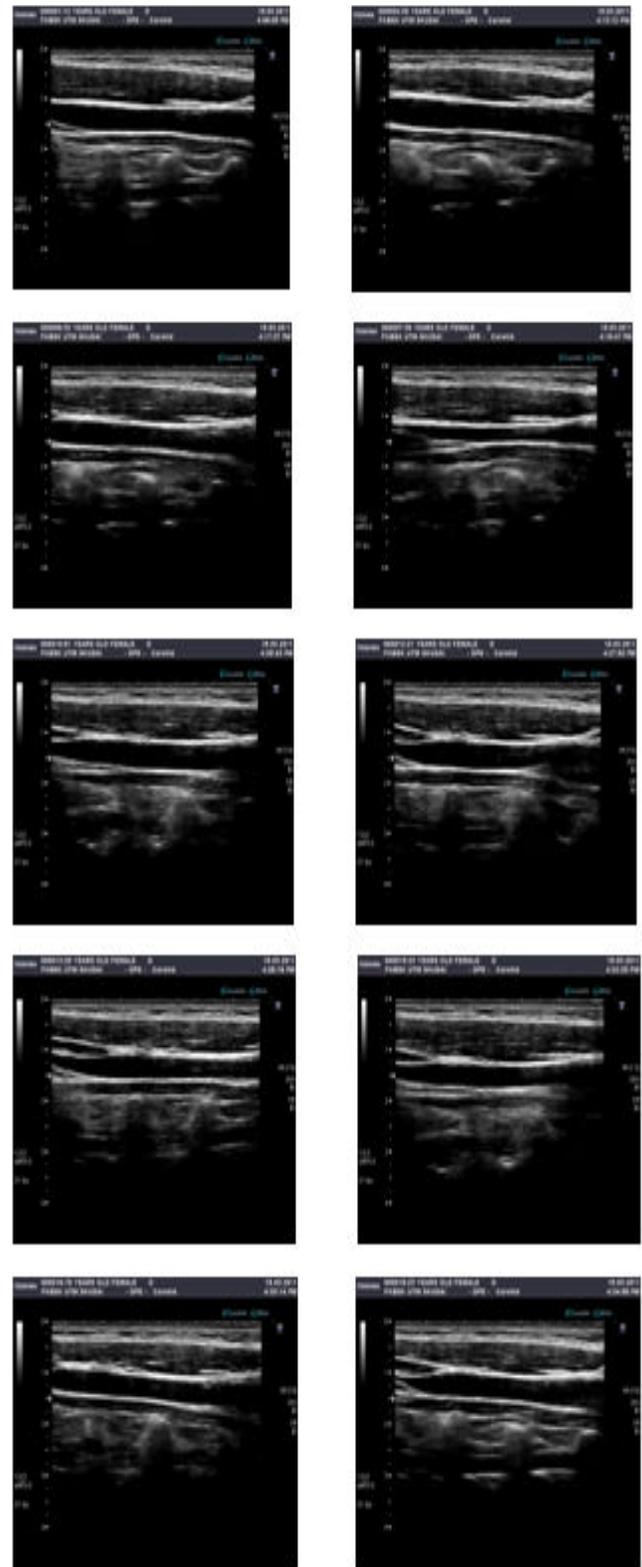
Ten female carotid artery ultrasound images
